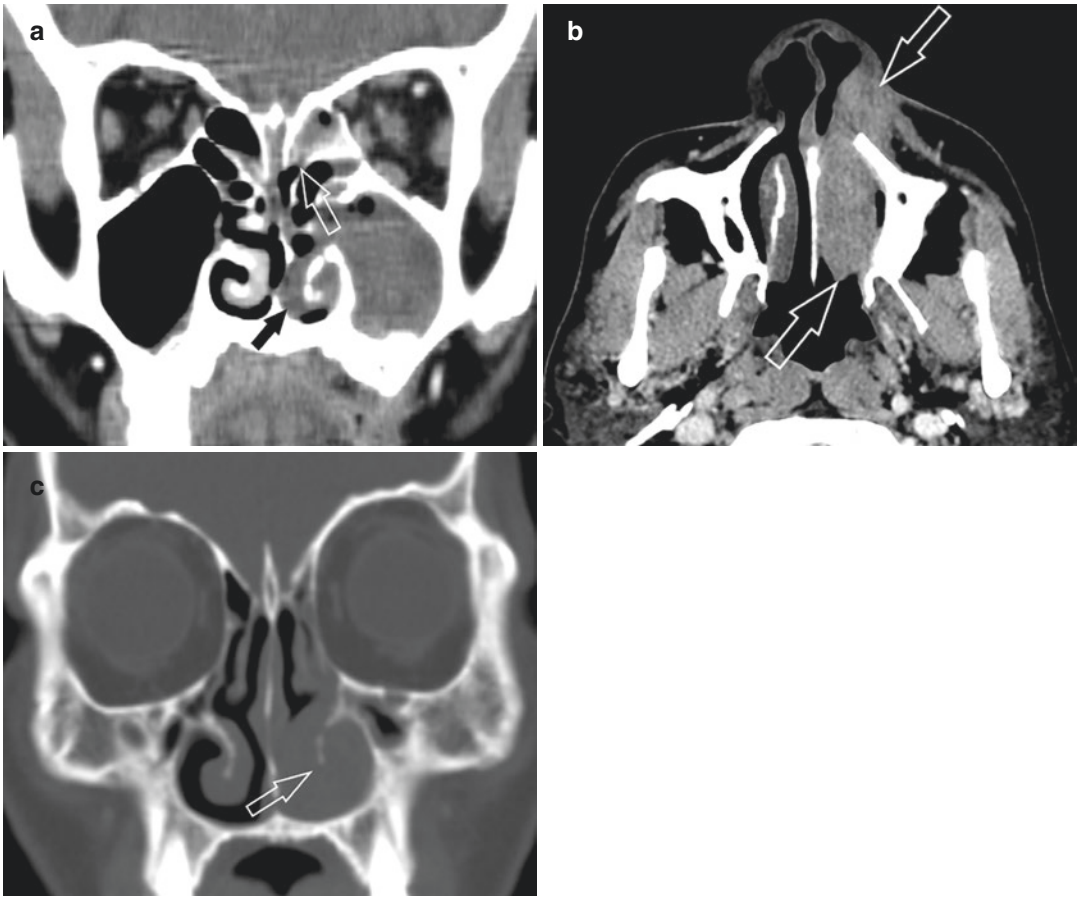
Invasive fungal sinusitis in two different patients. (a) Acute invasive fungal sinusitis from *Rhizopus* species. Coronal contrast-enhanced CT image shows enhancing mucosal thickening in the left nasal cavity and left ethmoid sinus (open arrow) and opacification of the left maxillary sinus. Note nonenhancing mucosal lining of left inferior turbinate (black arrow) from ischemia (compared to the enhancing mucosa on the right side) which help
